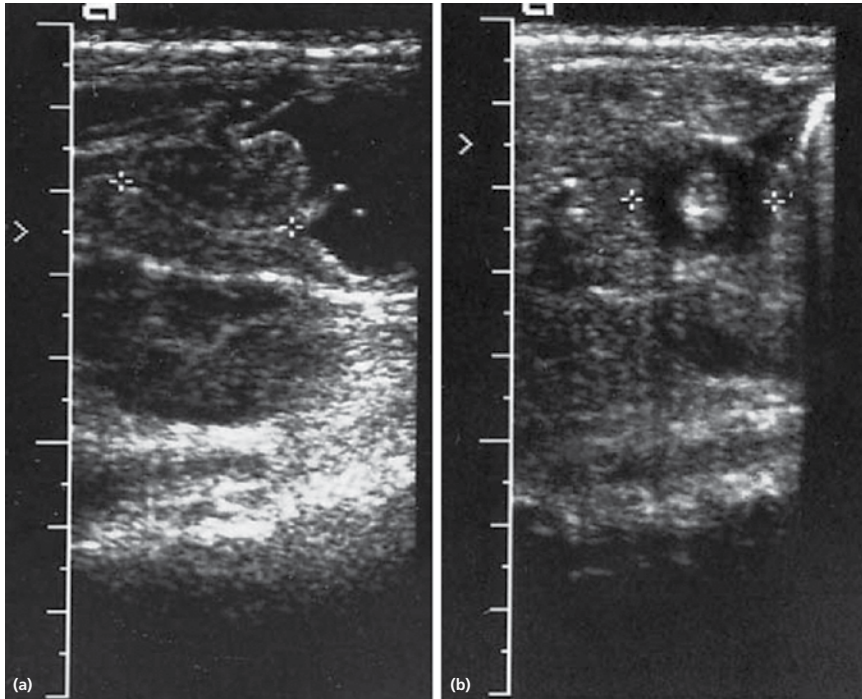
Ultrasonographic diagnosis of pyloric stenosis shows the thickened circular pyloric muscle in (a) longitudinal and (b) transverse plane.
